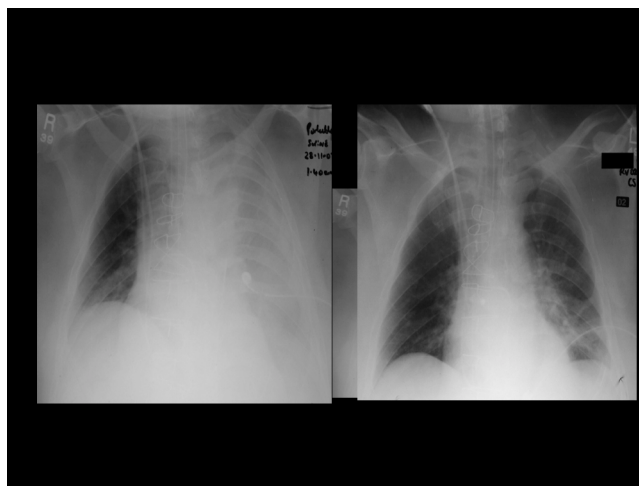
Supine radiograph. Left pleural effusion before and after manipulation of chest drain.
